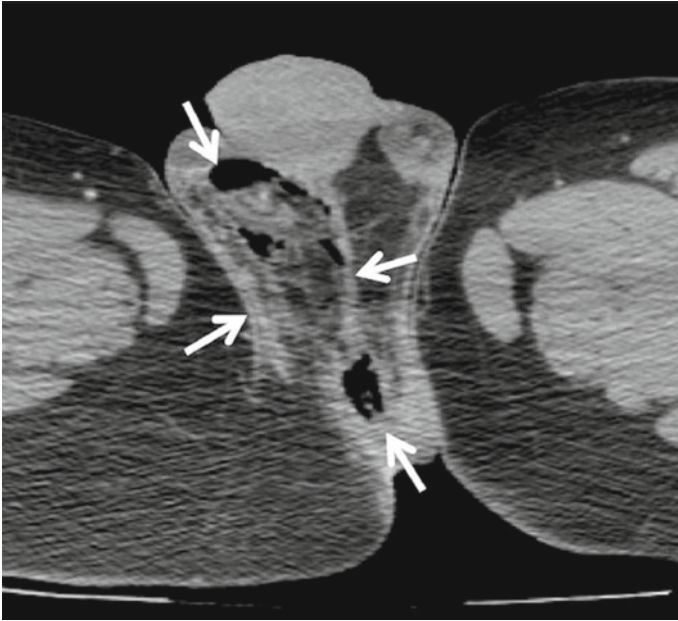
Fournier gangrene on CT, with inflammation and gaseous changes in the scrotal wall (arrows)²³
